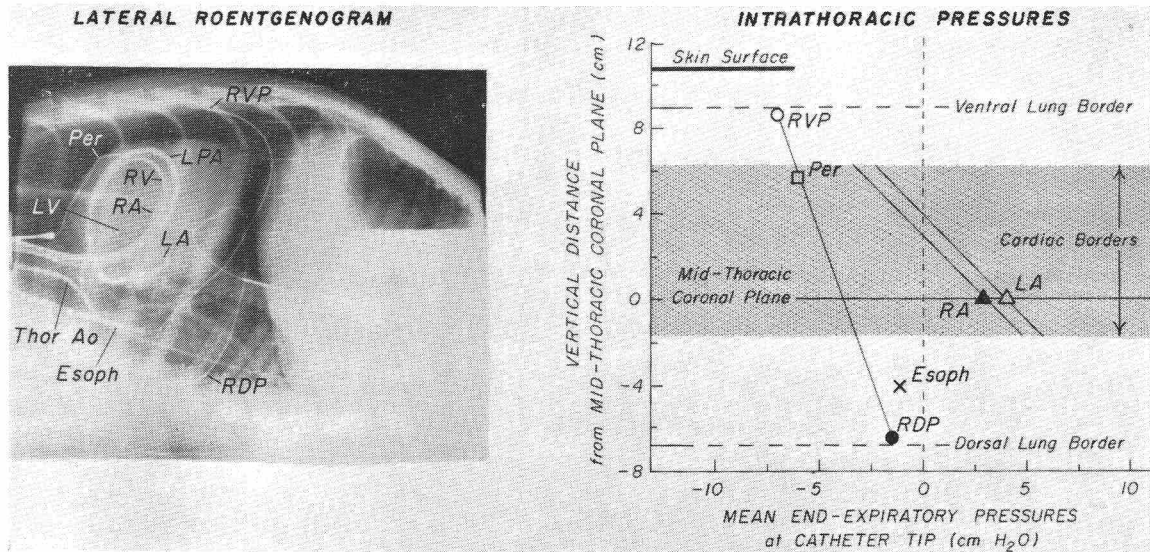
Lateral roentgenogram (left panel) and graph (right panel), based on this roentgenogram, showing vertical relationship of recording catheters to borders of the heart and lungs and relationship of pressures recorded at these sites to vertical distance from midcoronal plane of the thorax. Note intrapleural pressure gradient of about 0.5 cm H₂O/cm of vertical distance between ventral (RVP) and dorsal (RDP) surfaces of the lung. Pressure
